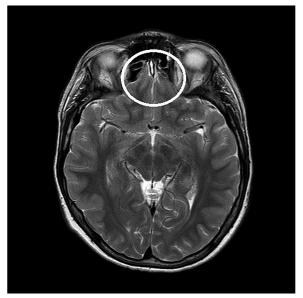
MRI of the brain, axial plane, showing hypoplasia of the olfactory bulbs, more on the left side (white circle).*
